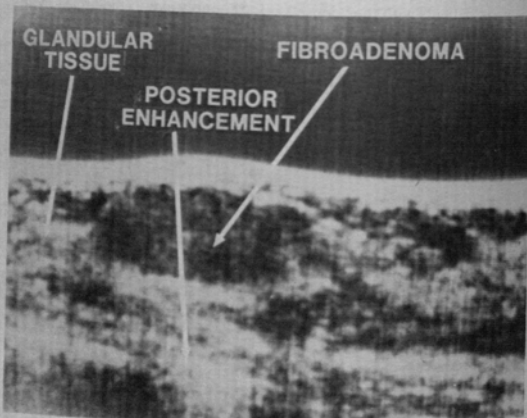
Ultrasound image of fibroadenoma in breast of a young patient. Note the homogeneous internal echoes of the mass.
